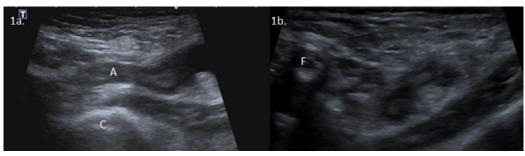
Ultrasound of the inguinal region along the longitudinal axis (1a) and the transverse axis (1b).
